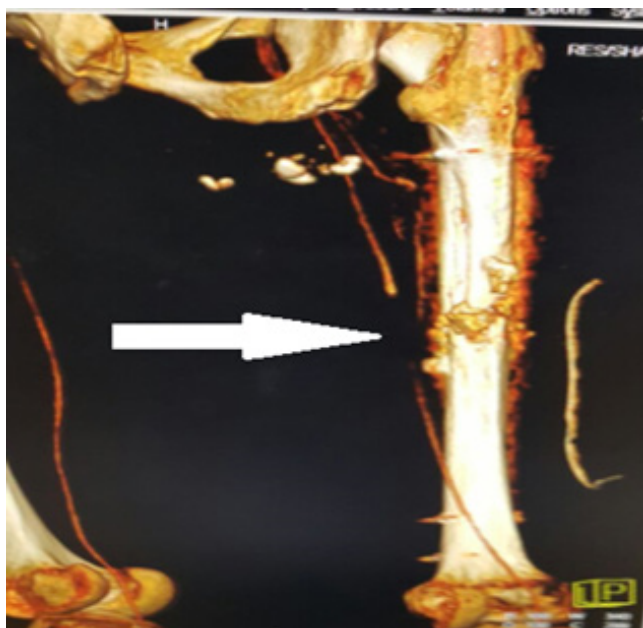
Filling defect on the SFA on CT angiogram
